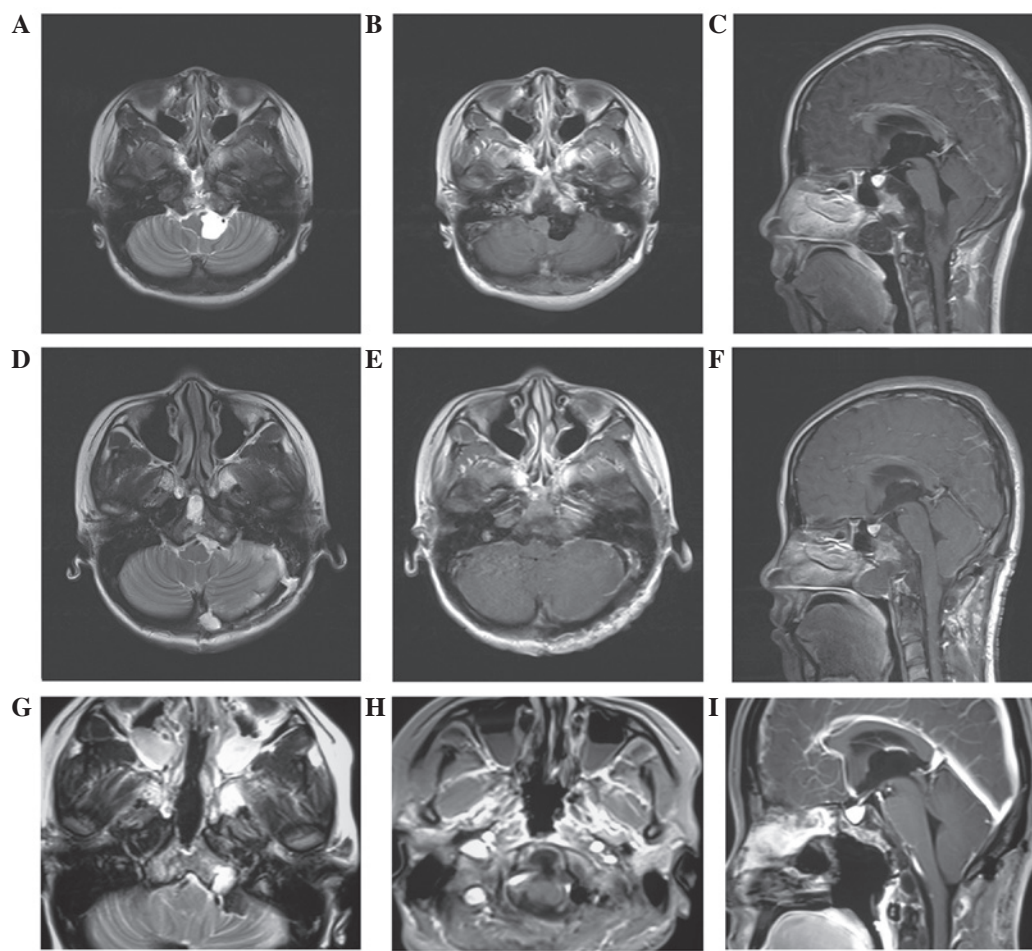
Magnetic resonance imaging (MRI) of the skull base chordoma using T2-weighted axial MRI, and enhanced axial and sagittal MRI. (A-C) Skull base chordoma involving the nasal regions and clivus, revealing the lesion compressing the brain stem from the left side. (D-F) MRI after the first surgery showing the total resection of the intracranial region. (G-I) MRI after the staged surgery showing a subtotal resection.
